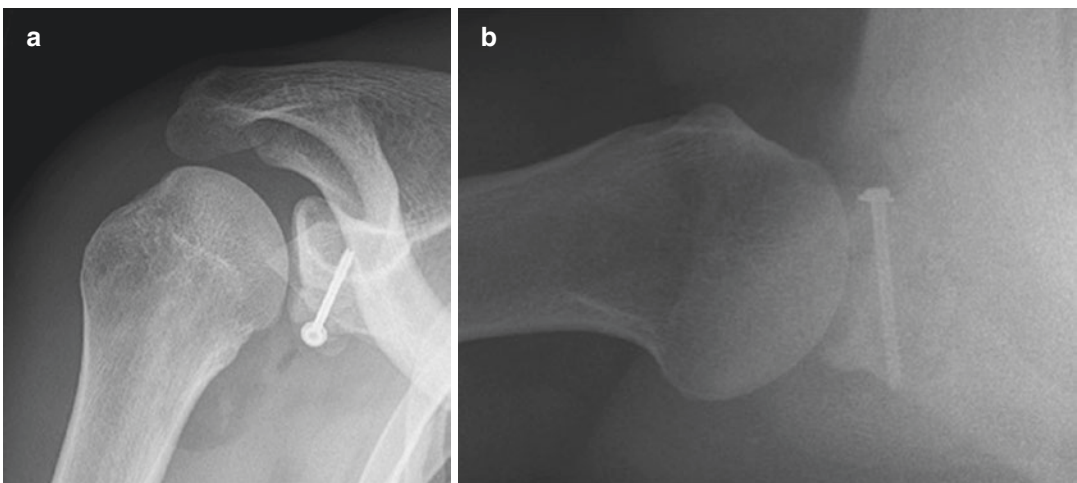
(a and b): Coronal and axillary radiographs following the patient's Latarjet demonstrating excellent screw placement and position of the coracoid
